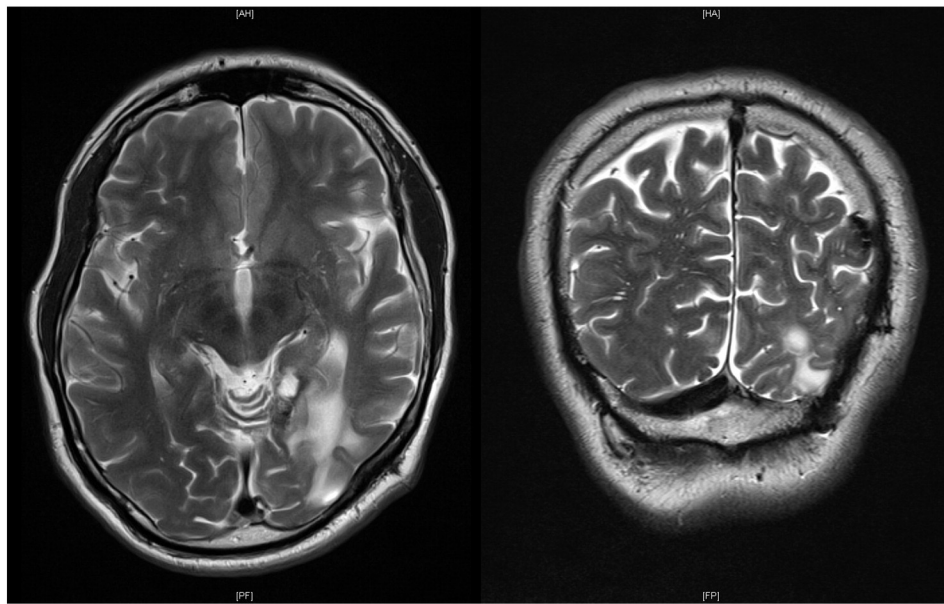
Axial and coronal oriented T2w MR images of the lesion in Case B; T2w hyperintense area (gliosis) in the left occipital and parietal lobes as a postoperative residue after removal of a left tentorial meningioma; part of the posterior horn of the left lateral ventricle is seen on the coronal view directly adjacent to the gliosis due to vacuolization.
